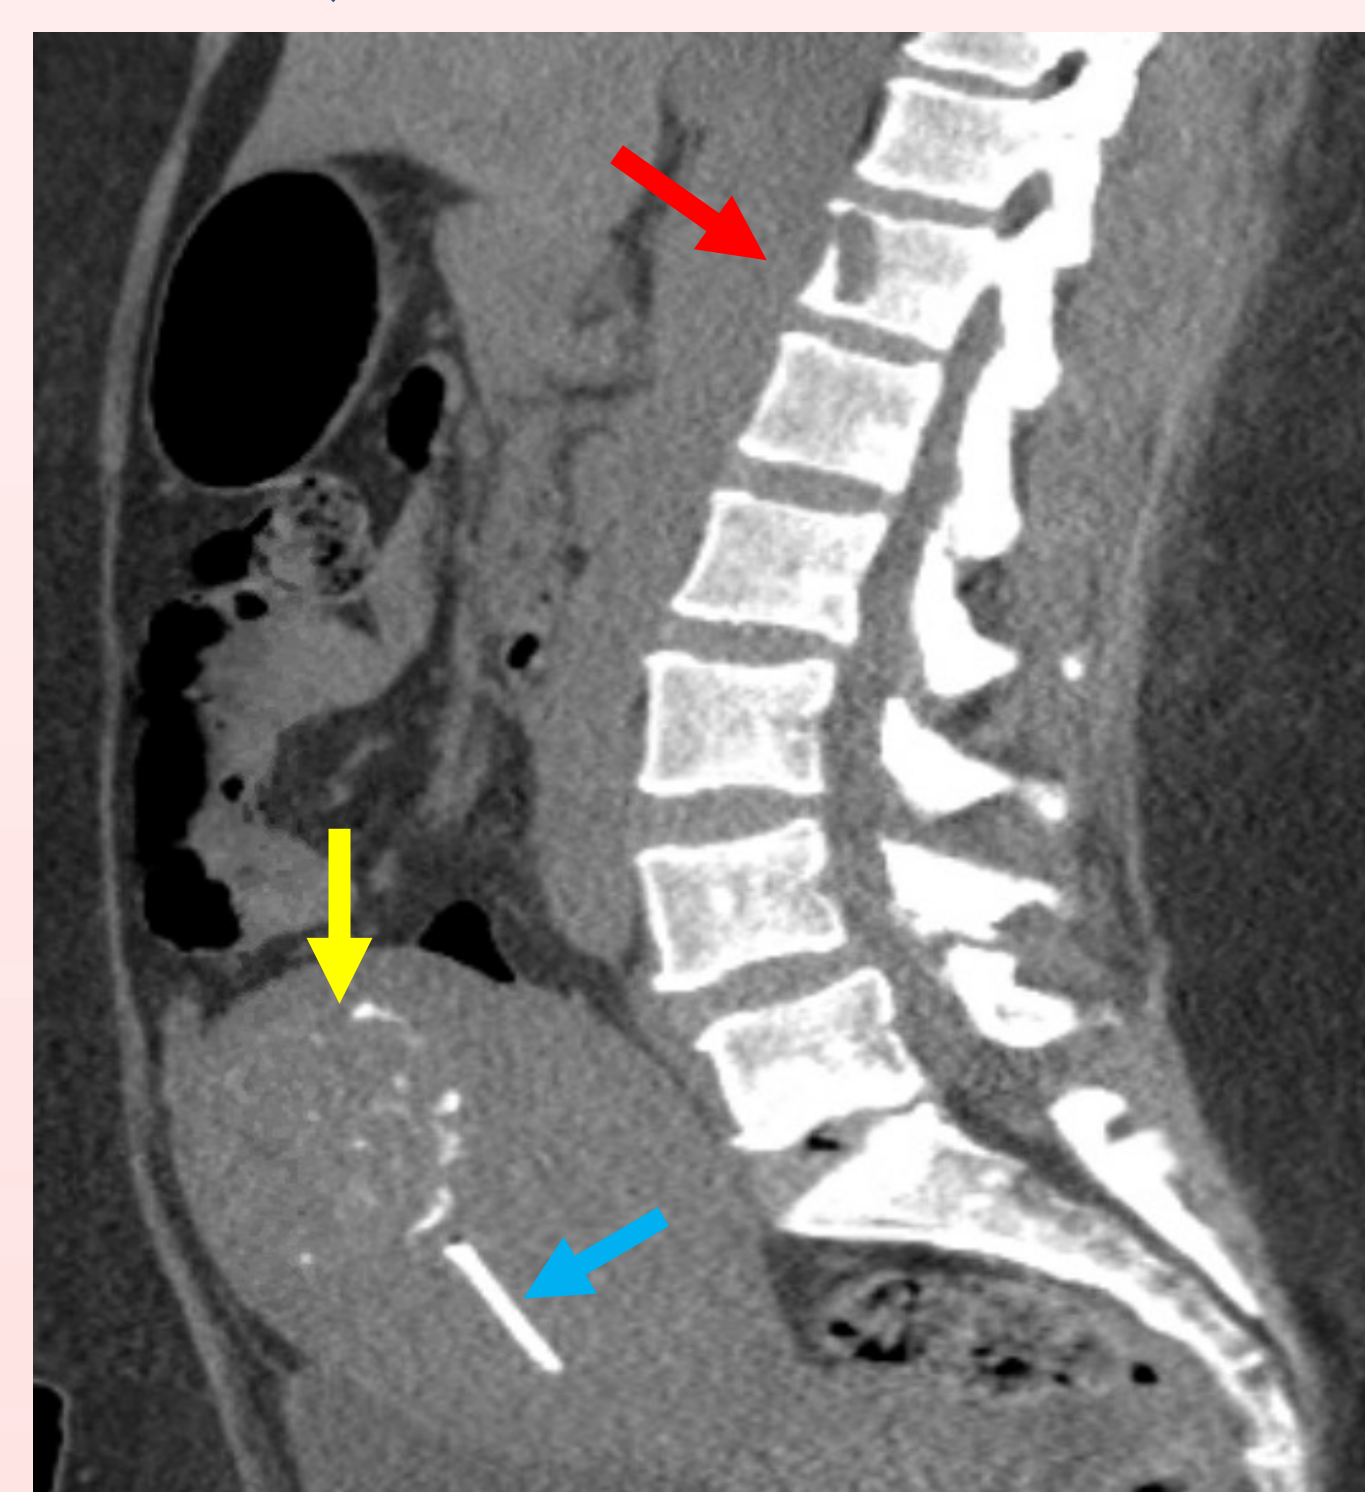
CT showing T6 osteolytic lesion (red arrow), calcified fibroid (yellow arrow), and IUD (blue arrow).
